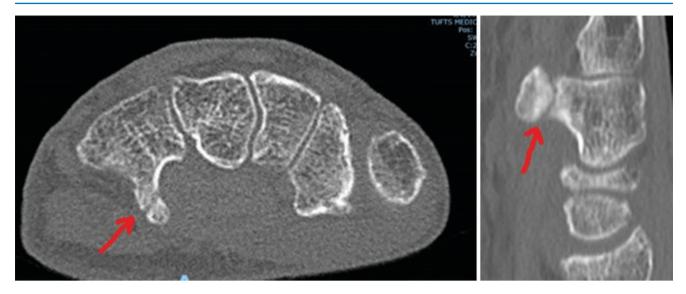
Axial and sagittal CT images of a patient with subacute fracture of the tip of the hamate hook. (Figures from author's library)
